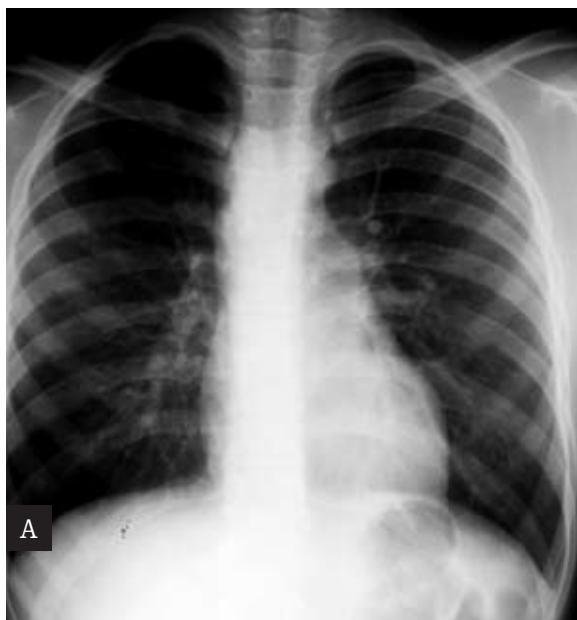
Boy, 13-year-old, with recurrent pneumonia and stridor; right-sided aortic arch with aberrant left subclavian artery. A. Chest X-ray: narrowing of the air column in trachea by right-sided arch. B. 3D reconstructed image: four branches of the aortic arch – left subclavian artery arising from Kommerrel’s diverticulum; vascular ring is tight. C. Axial scan on the level of the aortic arch: right-sided aortic arch with aberrant left subclavian artery (arrow) arising from the Kommerrel’s diverticulum (asterisk); tracheal narrowing.
